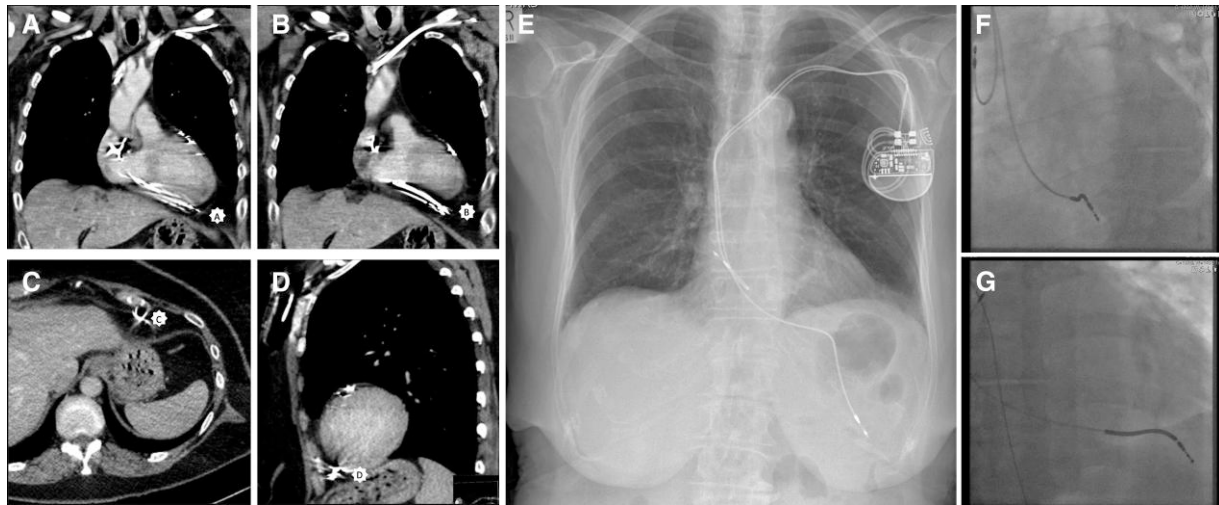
A–D: computed tomography post-contrast displaying lead tip perforation localization with review in three orthogonal views: A + B: coronal planes, C: axial plane and D: sagittal plane. All demonstrating the lead tip (denoted by *) traversing beyond the visceral pericardium and likely abutting but not extending beyond the parietal pericardium, visible even with some motion artefact. E: plain chest radiograph posteroanterior projection displaying perforation of right ventricular pace-sense lead beyond the parietal pericardium. F (left anterior oblique projection) and G (right anterior oblique projection): fluoroscopy images displaying inferior angulation of the right ventricular defibrillator coil extending beyond the cardiac contour, below the diaphragm.
